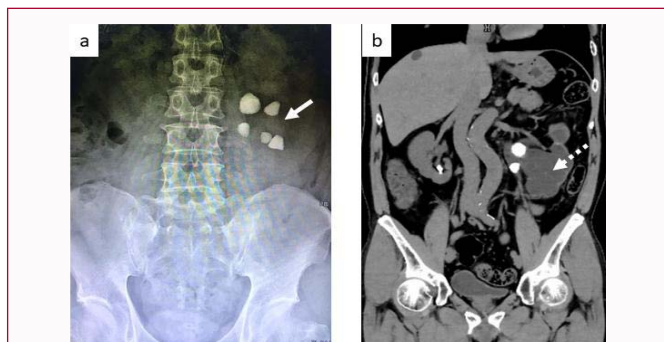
Preoperative image of KUB and CT. a) Arrow indicates large kidney stones including ureteral stone. b) Dot arrow indicates left atrophic kidney with hydronephrosis.
